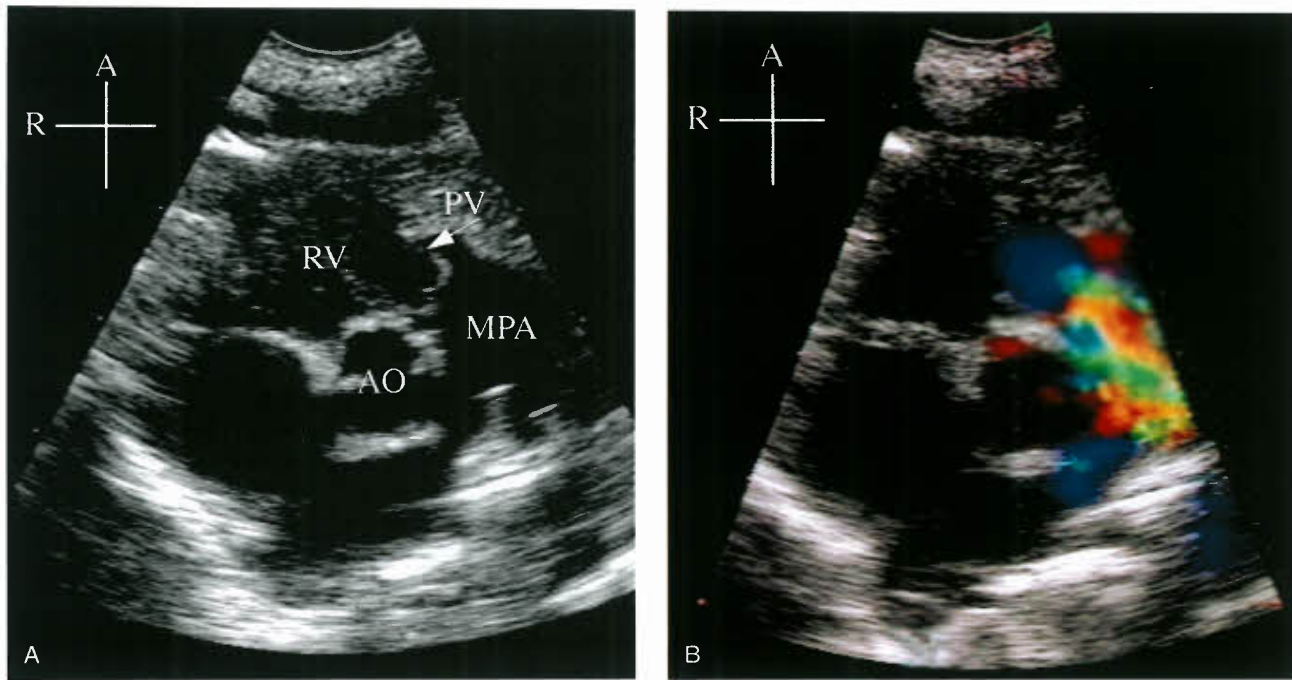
A: Parasternal short-axis view from a 1-day-old infant with critical pulmonary valve (PV) stenosis (same patient as in Fig. 40.3). Note the thickened, “doming” leaflets in systole. The PV annulus is hypoplastic compared with the aortic valve annulus. There is poststenotic dilation of the main pulmonary artery (MPA). B: Color Doppler through the stenotic PV shows a mosaic pattern indicating high-velocity, turbulent flow originating at the level of the PV. A, anterior; AO, aorta; R, right; RV, right ventricle.
